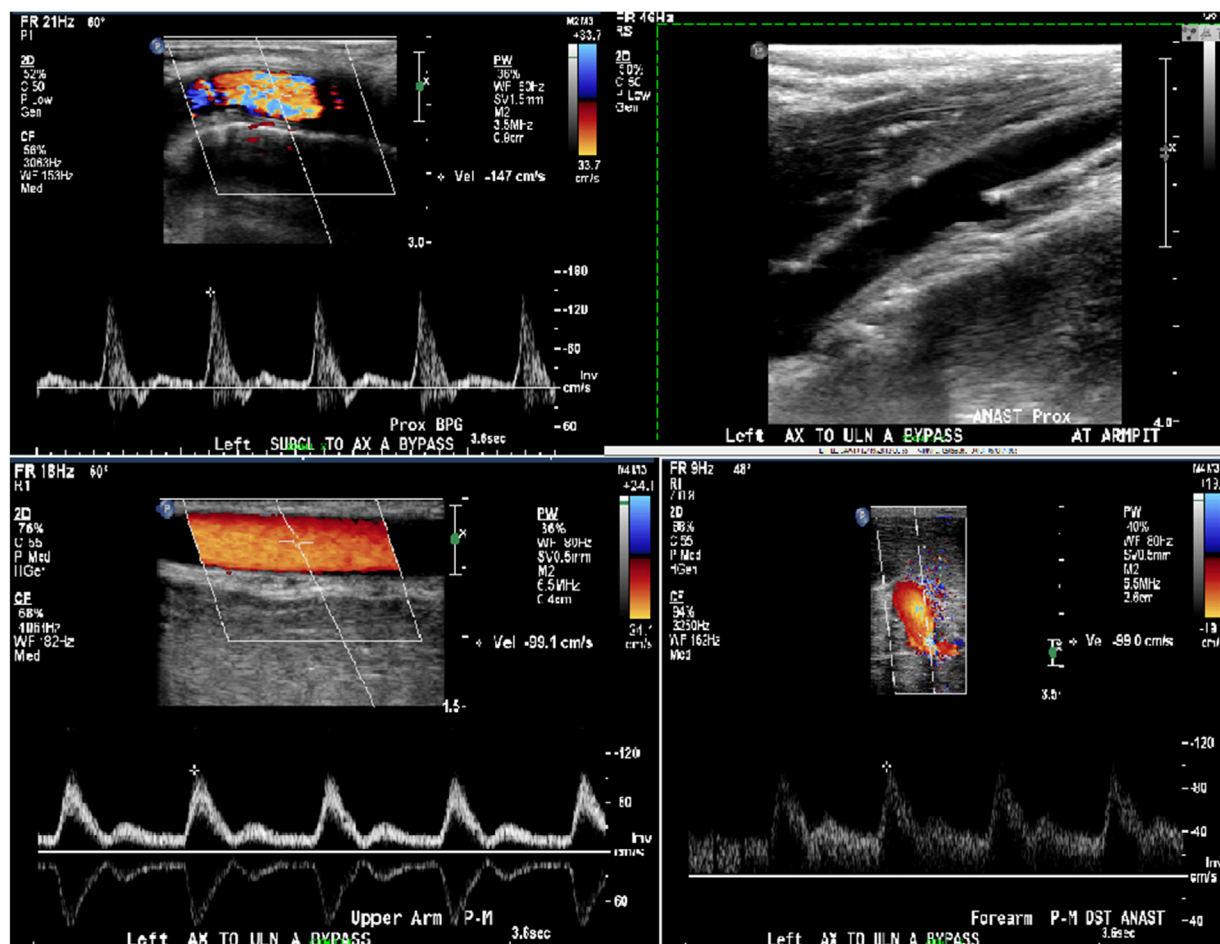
Left upper extremity arterial duplex ultrasound at 3 years postoperatively demonstrating patent left subclavian-axillary artery bypass and patent left axillary to ulnar artery bypass.
